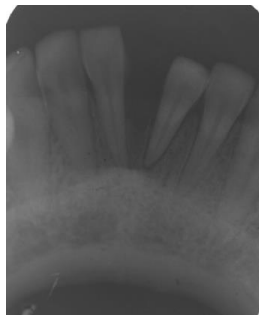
Radiographic Examination of the lesion
